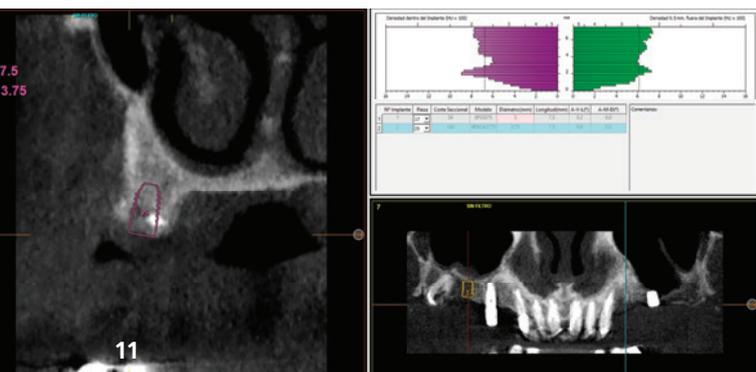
Planning of the second quadrant implant placed in the area of previous implant removal. Fig. 12: Panoramic radiograph after insertion of the new implants. The patient continued with his provisional prosthesis while waiting for the new implants to be loaded. Fig. 13: Radiograph with the new progressive loading prostheses with all implants integrated.
